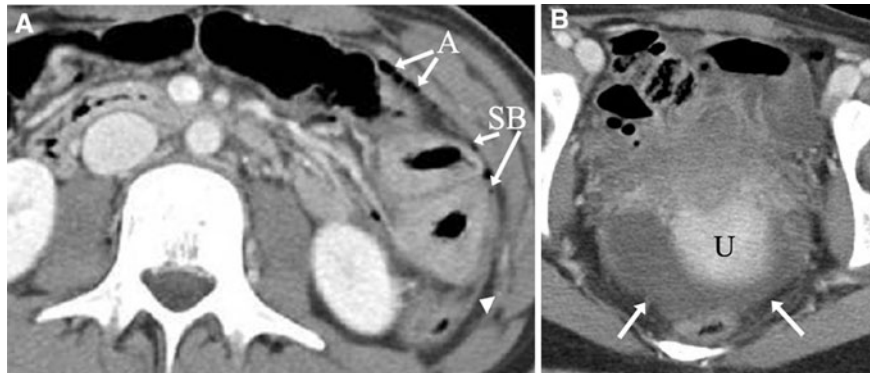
An 18-year-old female status post-blunt abdominal trauma. A Axial contrast-enhanced CT of the abdomen demonstrated wall thickening of small bowel loops (SB) in the left abdomen with adjacent fat stranding (arrowhead) and free
